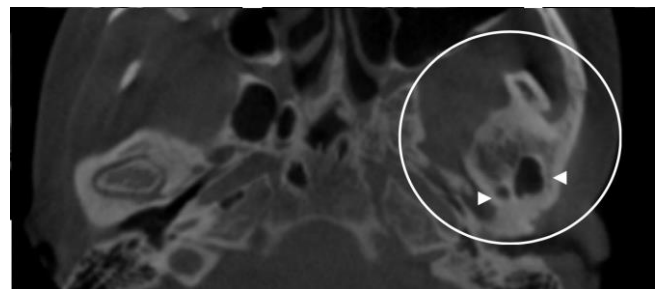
Axial view with CBCT showing no differentiation between the mandibular condyle, glenoid cavity and coronoid base. Pneumatization of the mastoid cells can also be observed.
